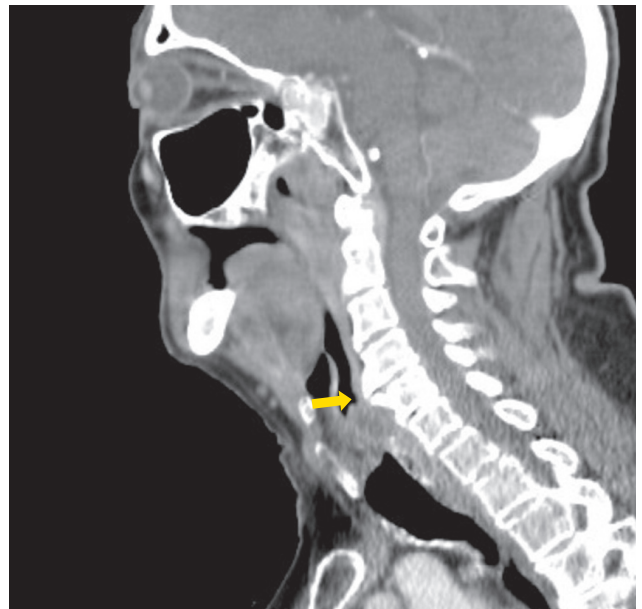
Contrast-enhanced neck computed tomography with marked anterior osteophytes in the C4-C5 vertebrae (arrow)
